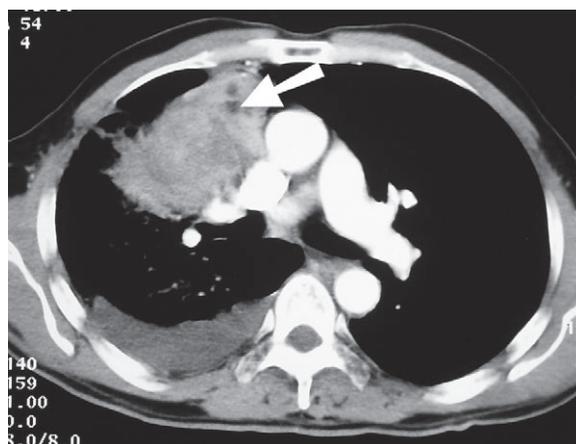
Contrast-enhanced CT: heterogeneous enhancement of the mass with a few small low attenuation foci indicating cystic and necrotic degeneration (arrow). The mass is abutting the superior vena cava and upper lobe vessels.
